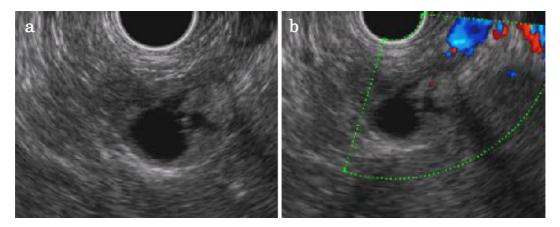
Curved linear array endoscopic ultrasonography demonstrating a slightly high echoic component compared to the pancreas parenchyma, with a cystic lesion (a). It was difficult to puncture the mass while avoiding the rich perfusion of blood vessels around the mass lesion (b).
